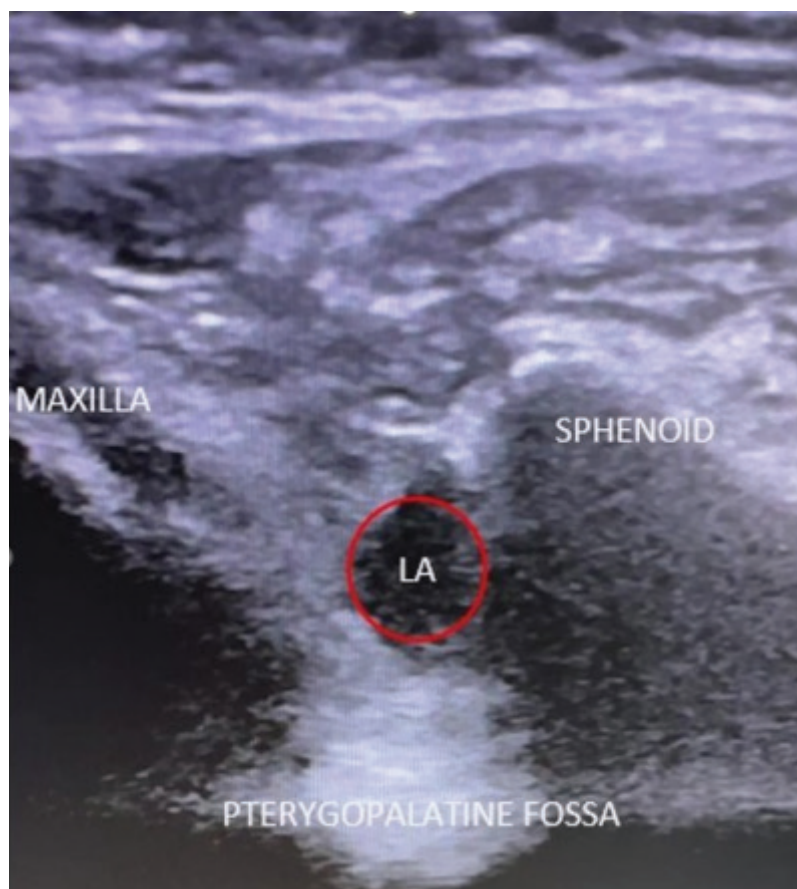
Sonographic picture showing the spread of local anaesthetic in the pterygopalatine fossa.
